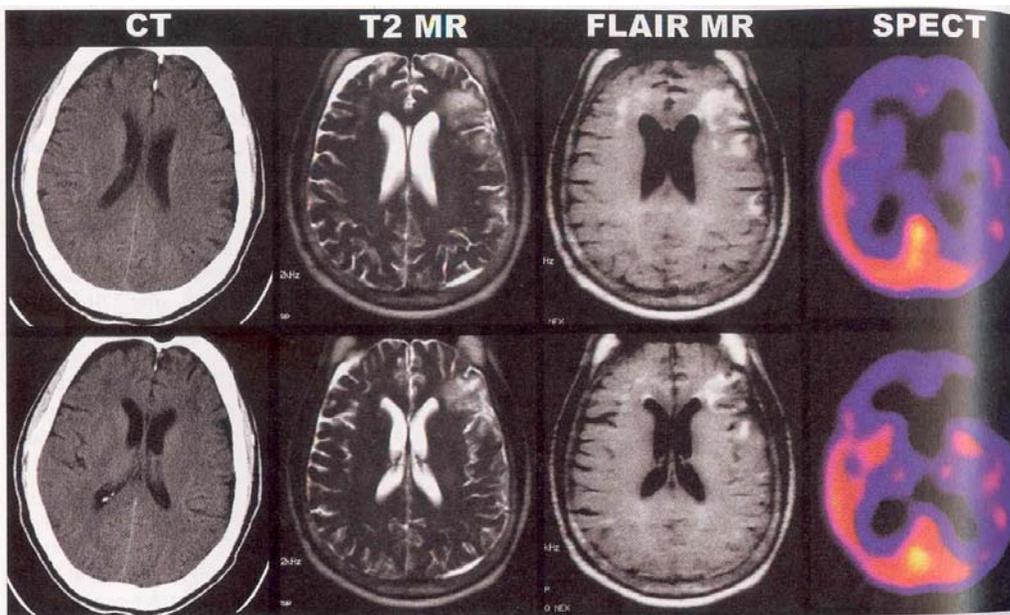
Early subacute presentation of traumatic brain injury on SPECT.
